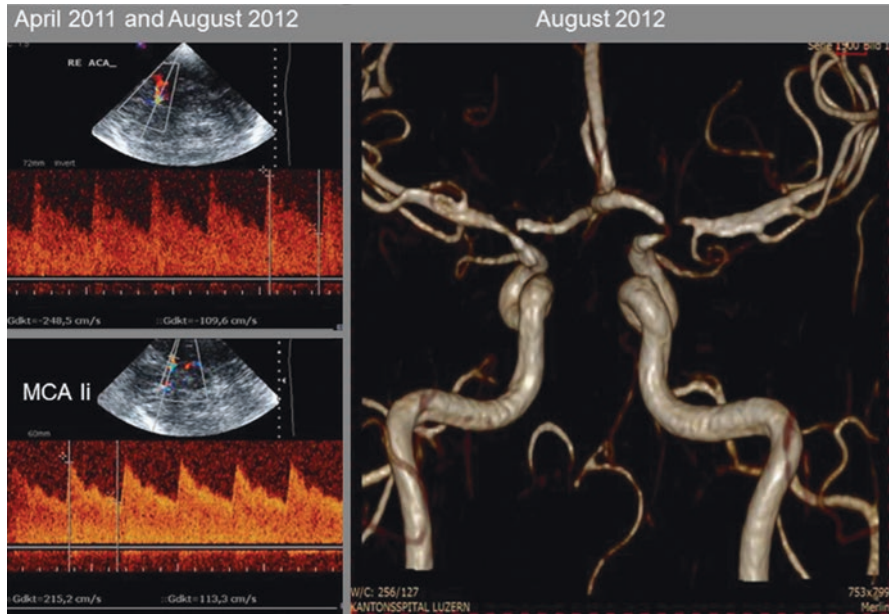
The time course of an intracranial tuberculous ICA-stenosis from its initial diagnosis to its chronic phase. On the left, the Doppler findings in April 2011 and August 2012: at both time points the cerebral blood flow velocity elevations were nearly identical in the right (re) anterior cerebral artery (ACA) and the left (li) middle cerebral artery (MCA). On the right, the corresponding magnetic resonance imaging angiography after 1 year of adequate therapy
